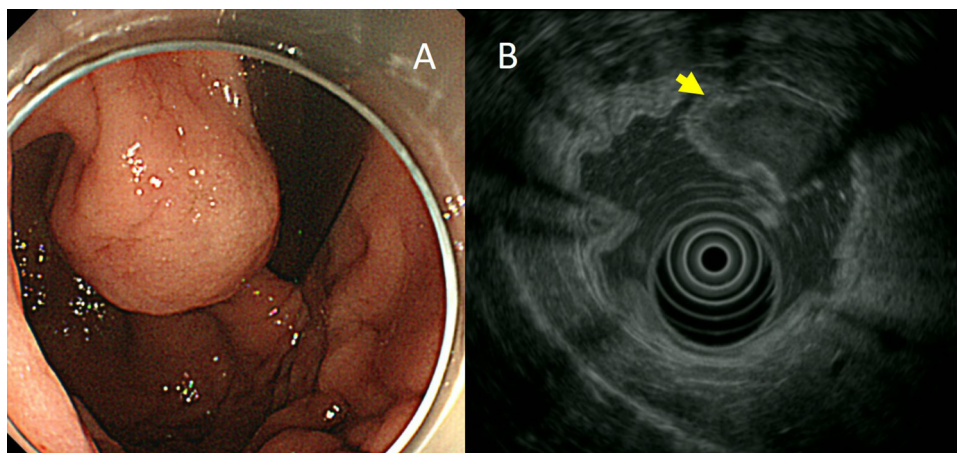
Upper gastrointestinal endoscopy revealing a submucosal tumor located in the lesser curvature of the upper body of the stomach (A). Endoscopic ultrasonography revealing an intraluminal hypoechoic tumor located in the third or fourth layer of the stomach wall (B).
